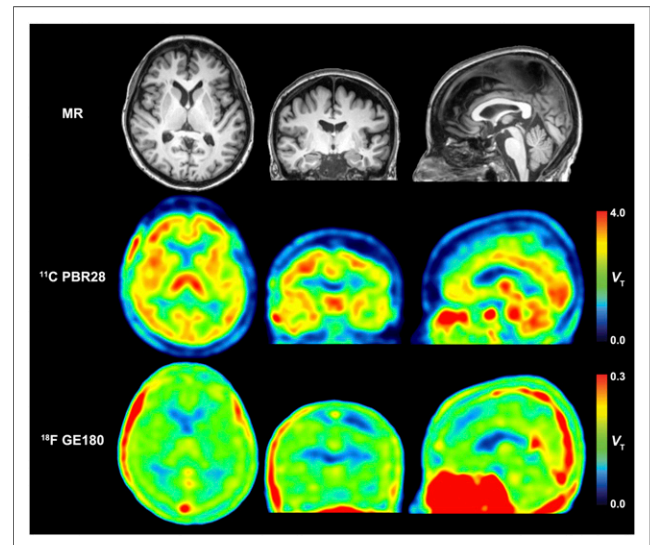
Parametric images of ^{11}C -PBR28 and ^{18}F -GE180, obtained with Logan plot, for healthy volunteer with high-affinity binding and corresponding MR images for anatomic reference. ^{18}F -GE180 had very low uptake in brain; therefore, vascular structures are prominently visible.
